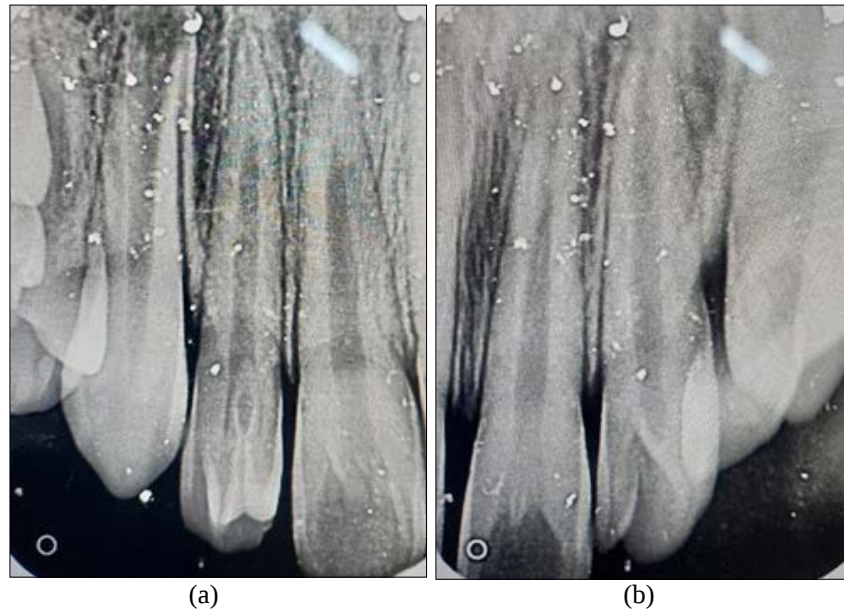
Periapical radiograph of maxillary (a) right lateral incisor (b) left lateral incisor showing dens invaginatus
